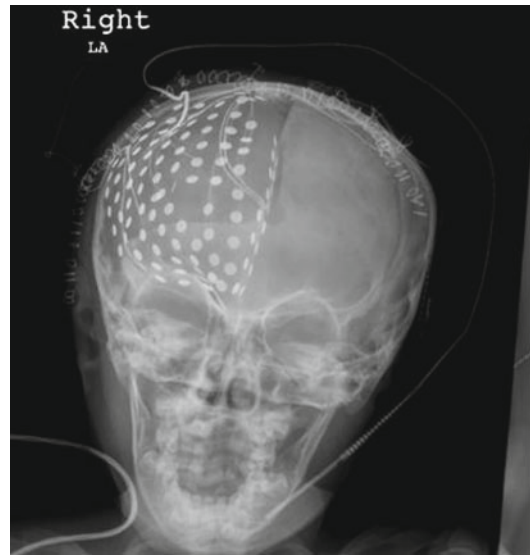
Skull x-ray showing postoperative subdural electrode placement
